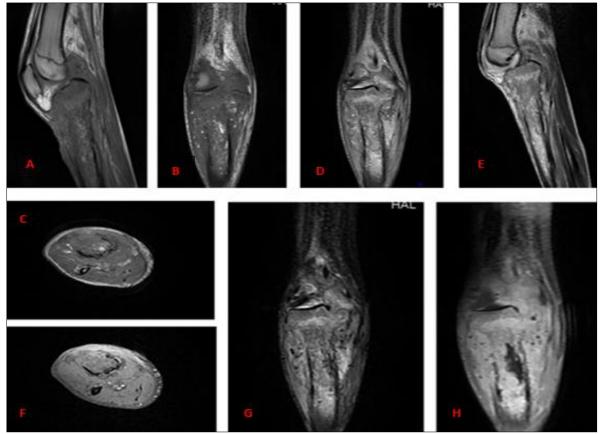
MRI of the right leg — sagittal (A), coronal (B), and axial (C) slices on T1-weighted sequence; coronal (D) and sagittal (E) slices on T2-weighted sequence; axial T1 FAT SAT (F); coronal STIR (G); and post-contrast T1 (H). These images demonstrate a centromedullary lesion involving the epiphyseal, metaphyseal, and proximal diaphyseal regions of the right tibia, appearing heterogeneously hypointense on T1-weighted sequences, heterogeneously hyperintense on T2 and STIR sequences, with heterogeneous enhancement after gadolinium administration
